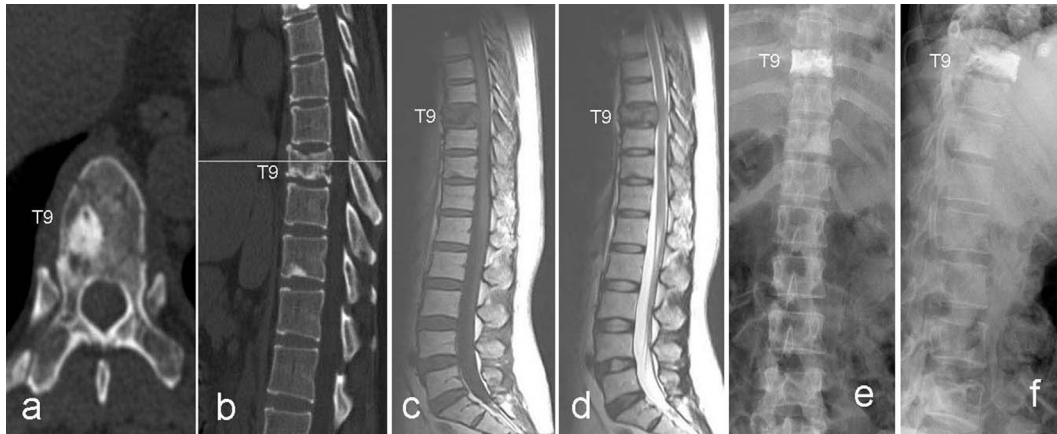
Preoperative CT (a,b), MRI scans including T1 and T2 sequences (c,d) and postoperative X-ray (e,f) in kyphoplasty for the treatment of osteoblastic metastatic vertebral lesions.
